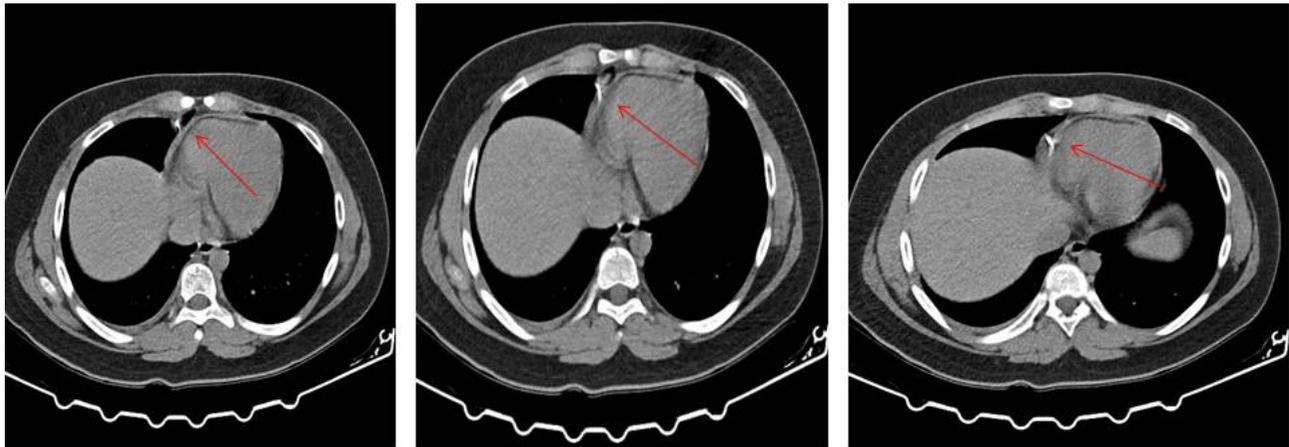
Right pleural effusion indicated by arrow and linear high-density foreign body adjacent to the right ventricle are seen in the heart computed tomography image
